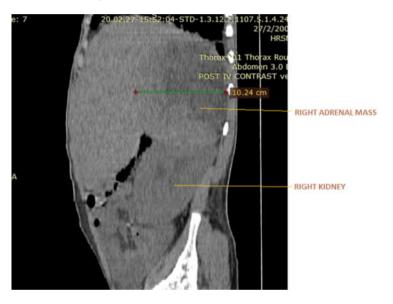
Sagittal view of the abdominal CT scan
